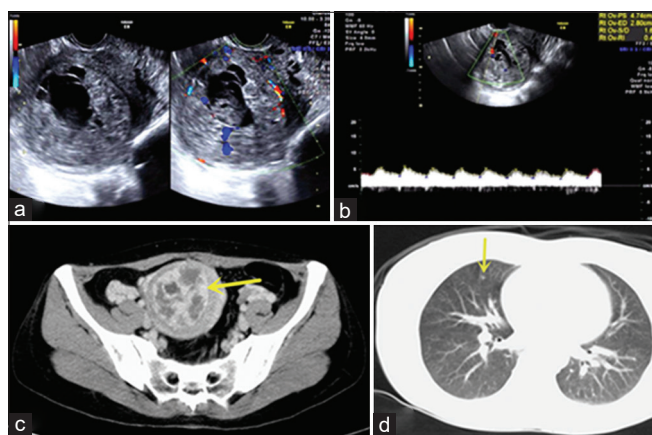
(a) The transvaginal ultrasound shows a heterogeneous hyperechogenic mass with a clear boundary in the middle to the upper uterine segment. (b) Point-like or line-like blood flow signals were detected around and inside the mass, RI = 0.41. (c) Abdominal enhanced computed tomography shows cystic and solid space-occupying lesions in the uterine cavity, with a clear flocculent heterogeneous enhancement in the right uterine wall and fundus uteri, reaching deep into the musculature. (d) Thoracic enhanced computed tomography shows a small nodule shadow of unknown nature appeared in the inner side of the middle lobe of the right lung
